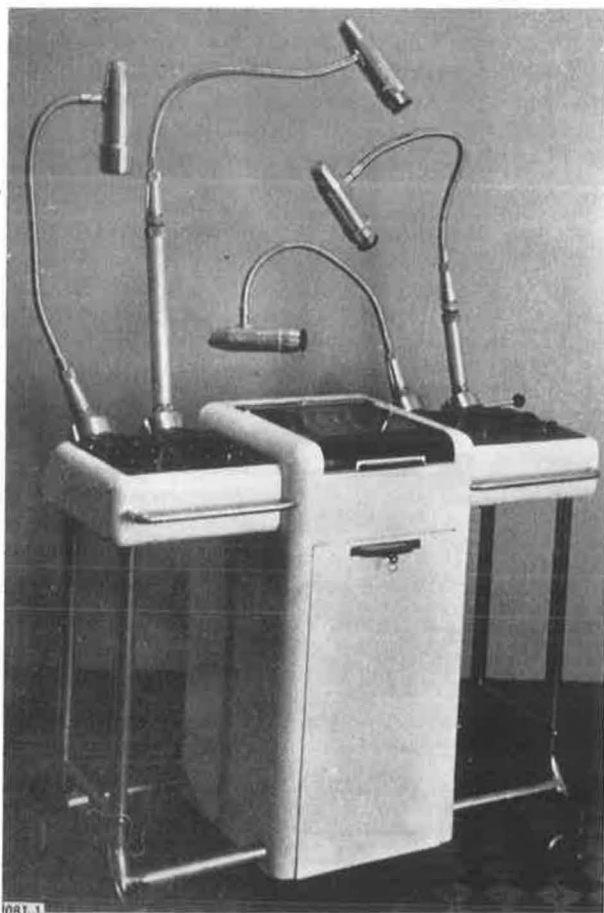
Four-channel radiograph; general view
